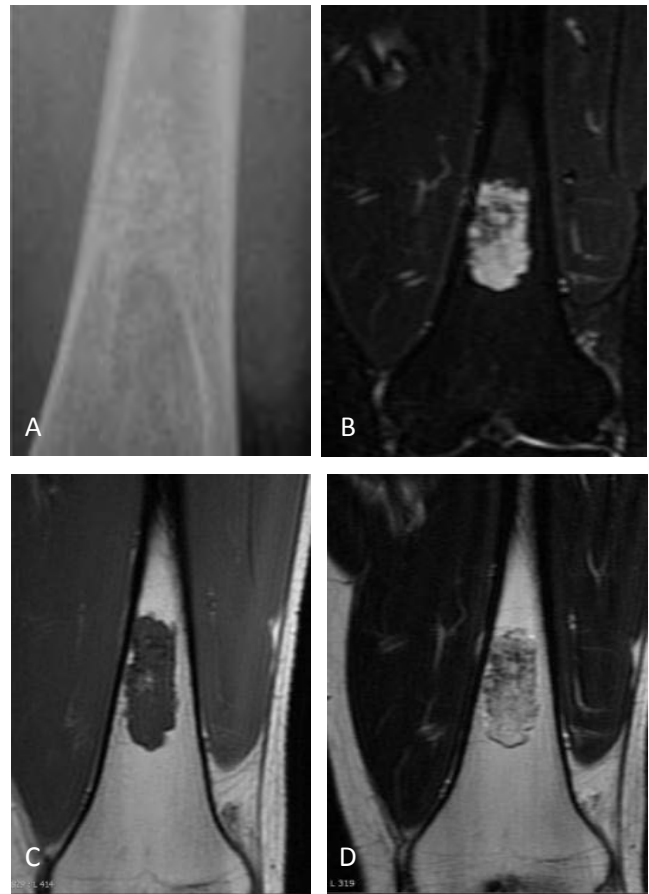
Enchondroma in an adolescent female. Coned-down AP radiograph of the distal femur (A) demonstrates a circumscribed lytic lesion with a narrow zone of transition and subtle calcifications in an “arcs and swirls” pattern along its superior margin. Coronal STIR image (B) reveals the lesion to be predominantly hyperintense with foci of hypointensity corresponding to calcifications. Coronal T1 pre (C) and post-contrast (D) images demonstrate a narrow zone of transition with enhancement throughout the lesion.
